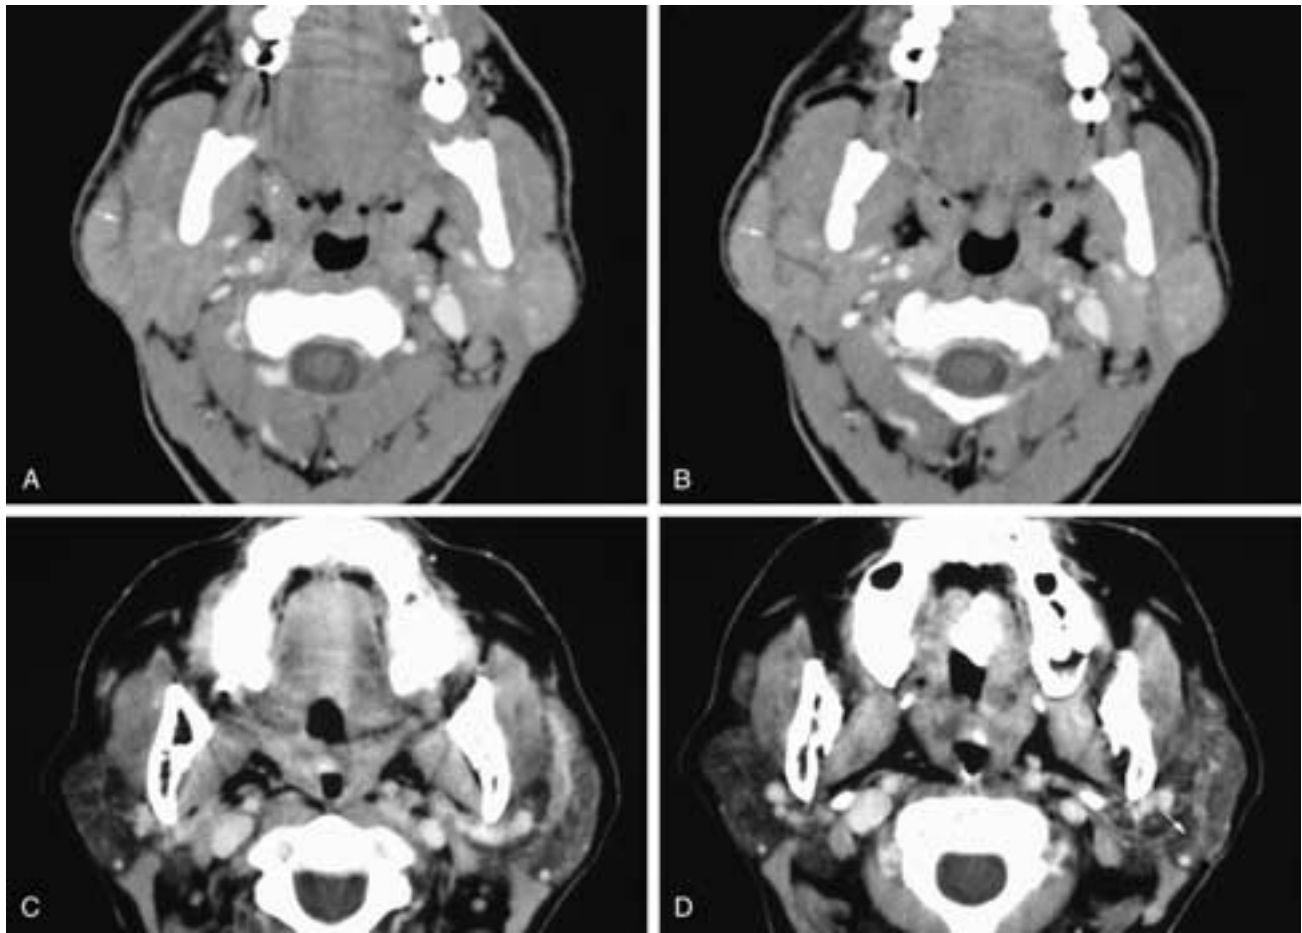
Axial contrast-enhanced CT scans (A, B) show minimal dilatation of the intraglandular ducts (arrows) within a slightly enlarged right parotid gland. This patient had very early right acute sialadenitis. Axial contrast-enhanced CT scans (C, D) show the early changes of a left sialadenitis. The left parotid gland parenchyma is denser than the normal right side secondary to edematous fluid and cellular infiltration. There is enhancement of the walls of the dilated intraglandular central parotid ducts.
